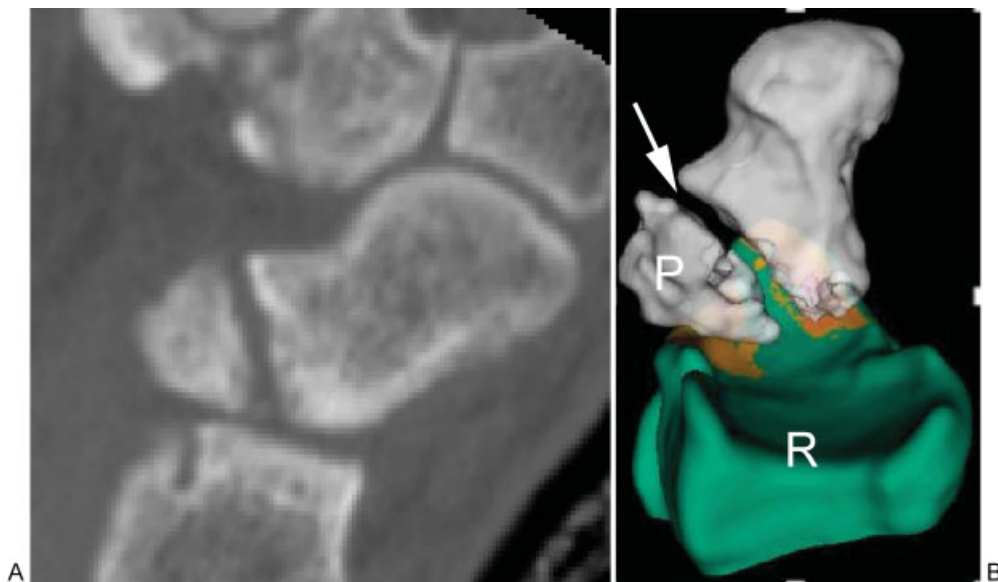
(A) Lateral computed tomographic scan showed a proximal partial coronal fracture nonunion. (B) Three-dimensional reconstruction highlighting the nonunion and fracture plane at 65 degrees (arrow). P, proximal scaphoid pole; R, radius.
